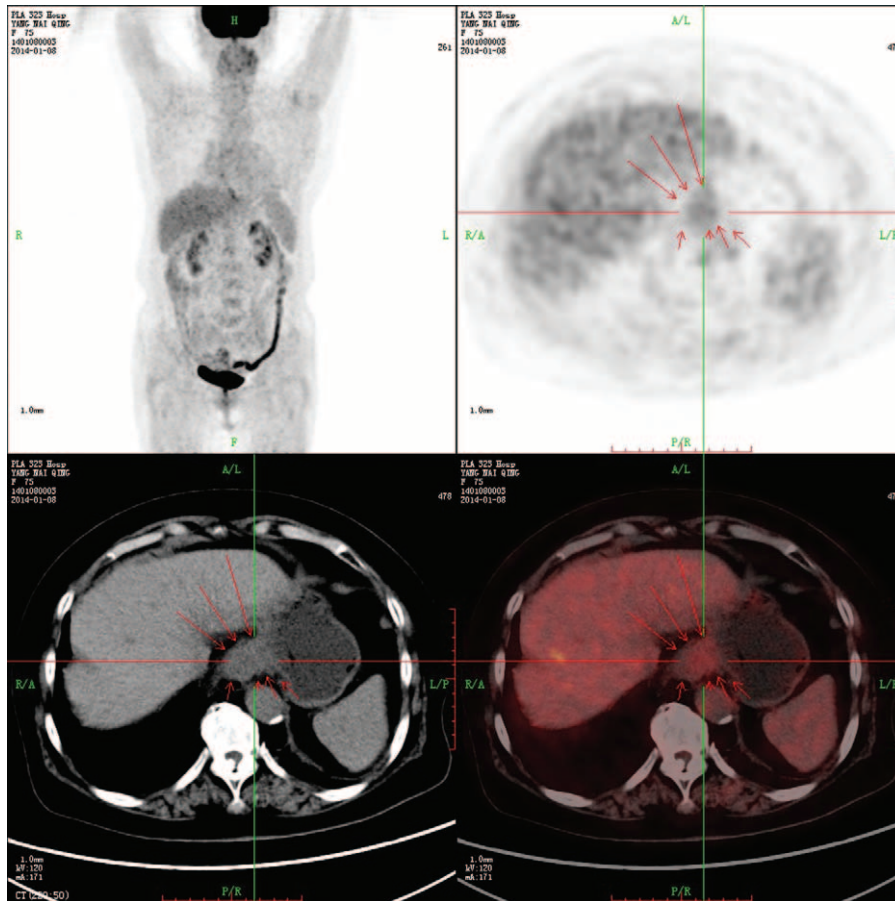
PET combined CT demonstrated that in spite of mild increased metabolism in lower esophagus, there was no sign of obvious tumor-specific performance and no tumor metastasis in the rest of the viscera tissue. CT = computed tomography, PET = positron emission tomography.
